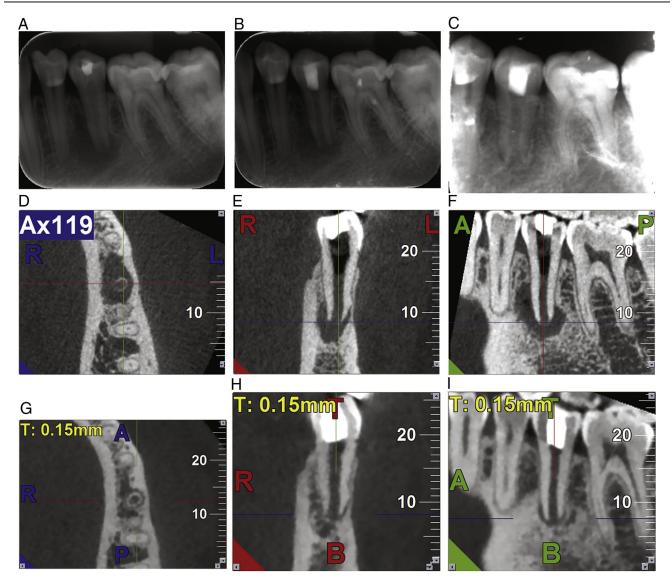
Periapical radiographs and CBCT sections of tooth #20. (*A*) Preoperative periapical radiograph showing extensive periapical radiolucency and open apex. (*B*) Radiograph taken at the 8-month recall. The periapical lesion has not changed in size. (*C*) Periapical radiolucency resolved 30 months after the initial treatment as shown on this periapical radiograph. (D–F) Preoperative CBCT scan. Images from different angles showed the extent of bone defect. (G–I) Thirty-month follow-up CBCT scan revealed bone healing around root apex. Root length and thickness remain unchanged compared with preoperative CBCT examination. The *yellow* T indicates image thickness; the *red* T indicates top aspect. A, anterior aspect; B, bottom aspect; P, posterior aspect; R, right side.
